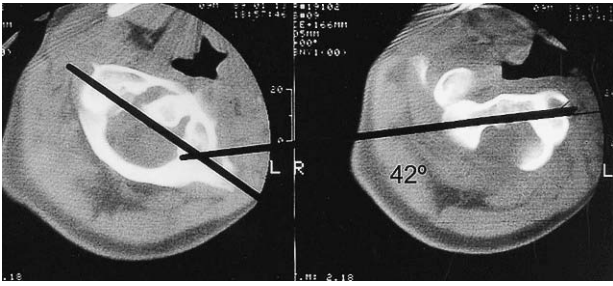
Axial CT scan of patient n°1 showing the measurement method with a 42° atlanto-axial divergence.
